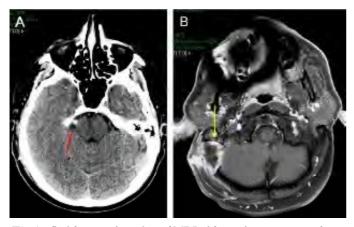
Gadolinium enhanced axial MRI of brain showing trigeminal nerve of right side (Red arrow).
